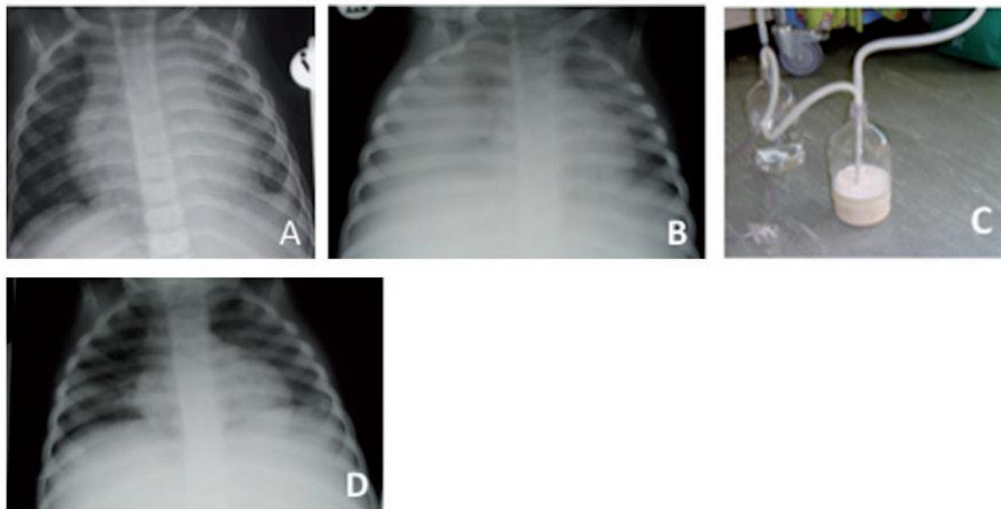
The course of illness from presentation to resolution of the cyclothorax. (A) Chest radiograph at presentation, (B) at the time of cyclothorax prior to insertion, (C) drainage from the intercostal drain and (D) after resolution and successful removal of the intercostal drain.
